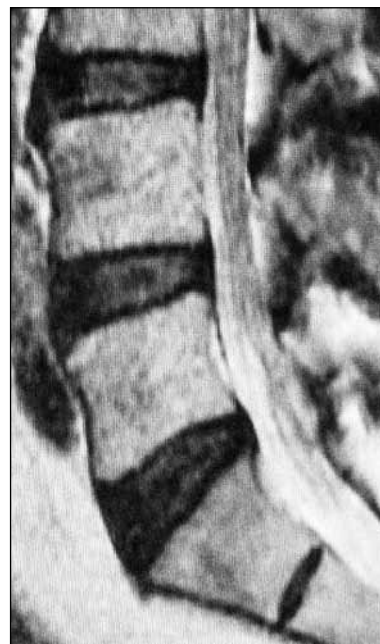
Sagittal T2 weighted MRI imaging of the patient before insertion of Gelstix™
